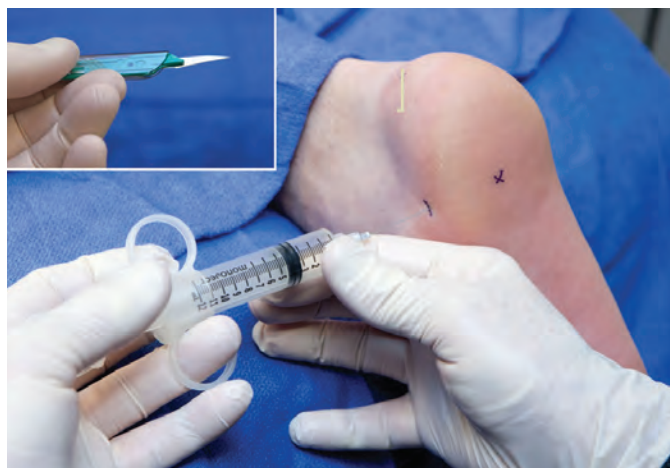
While several different techniques may be used, the area is anesthetized with a fast-acting local anesthetic under ultrasonic guidance. The skin is punctured with an 11-blade to facilitate the entrance of the ultrasonic probe.
